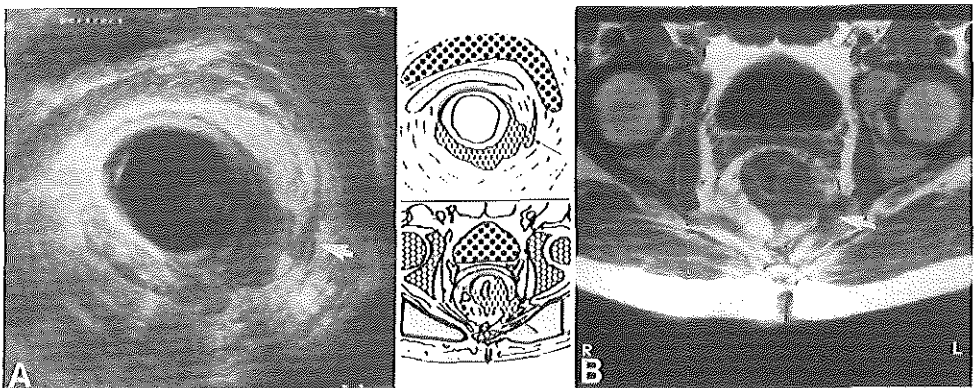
Rectal *pT2* tumor. Transrectal ultrasound (A) versus surface coil MRI (B). Overstaging, with both imaging modalities. Due to the thickening of perirectal septae (arrow), the tumor was staged as T3 with both imaging modalities.
